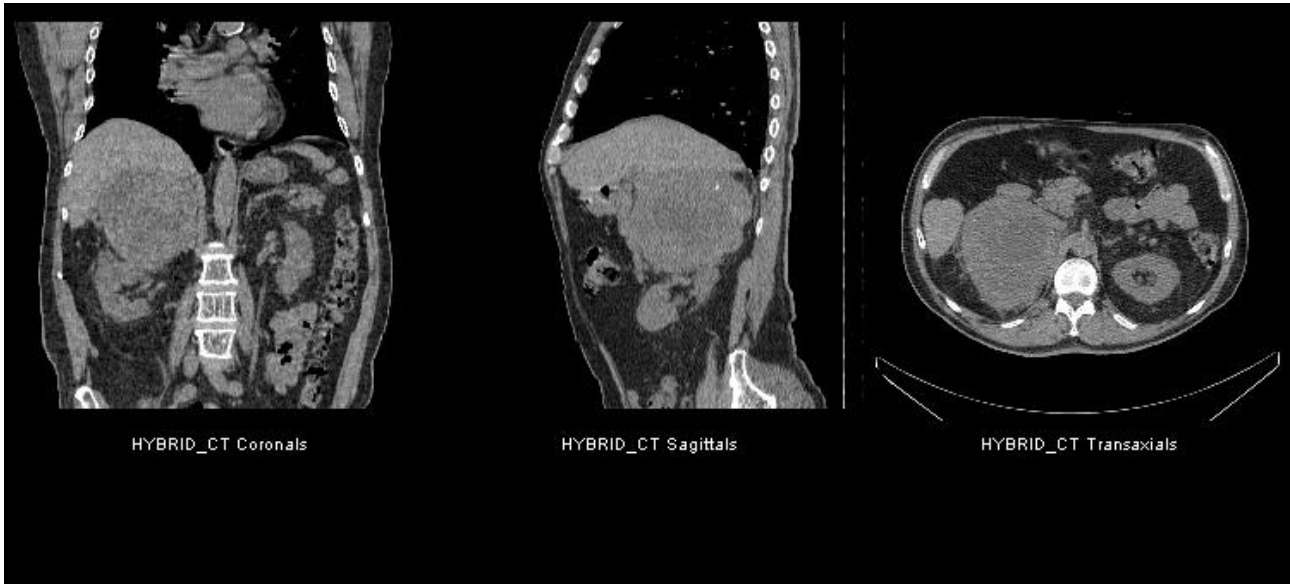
^{123}I mIBG SPECT/CT study of the lower thorax/upper abdomen. The SPECT only study highlights uptake of the radiopharmaceutical in the liver. With the addition of CT, the affected area of the liver becomes clearer and the SPECT uptake is also shown to correspond with features on the CT.
